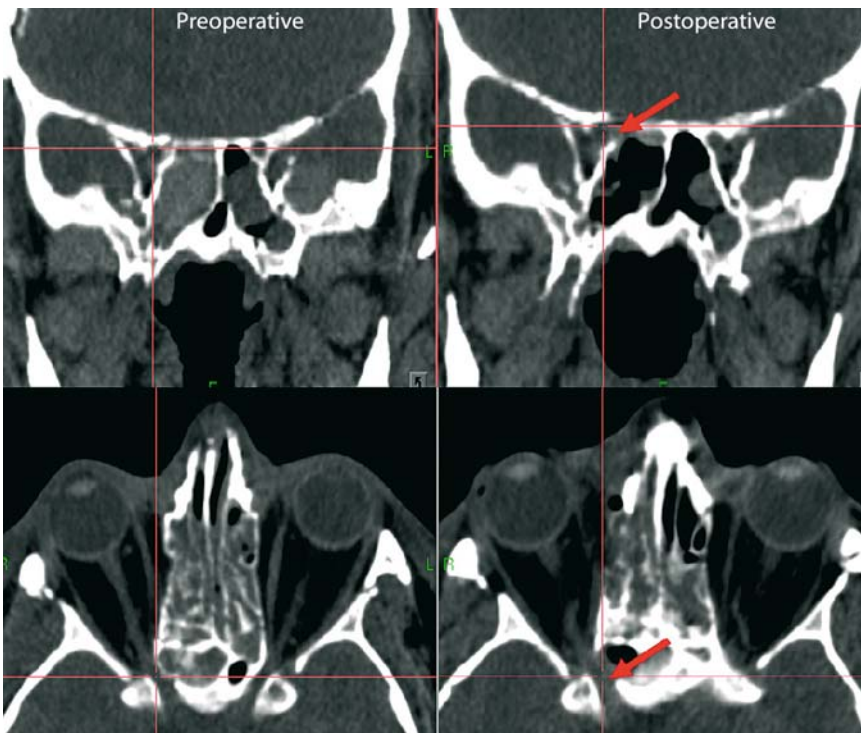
Postoperative evaluation of optic nerve decompression. The splint-based reference markers are used in correlating the preoperative (left) and postoperative (right) CT data sets. The arrows indicate the resection sites for optic nerve decompression in the postoperative data set
